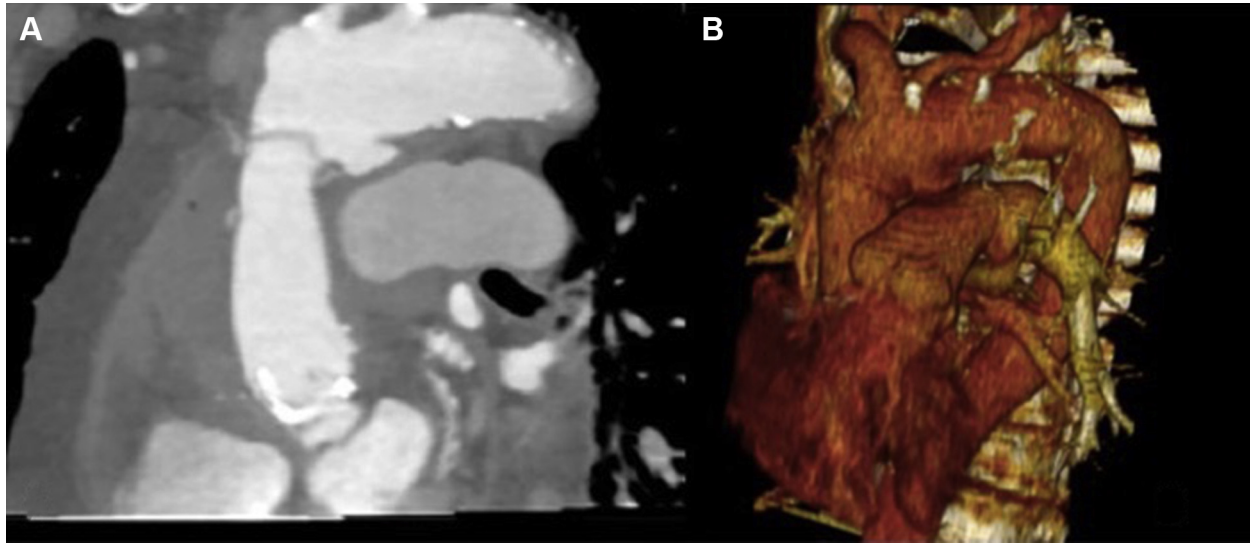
(A) Computed tomography angiogram shows aortic arch pseudoaneurysm at the level of the distal anastomosis. (B) Three-dimensional reconstruction shows compression on the pulmonary artery.
